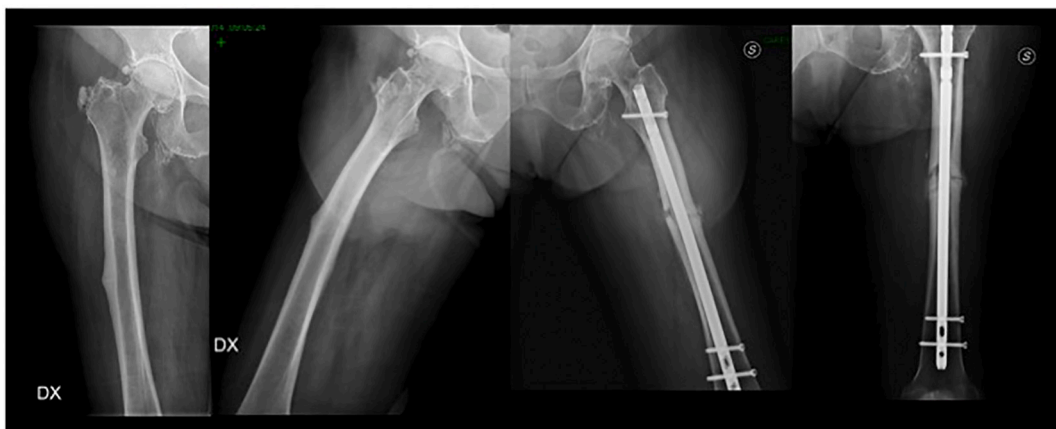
2-months follow-up radiographs. Right: right femur cortical beak. Left: dynamized intramedullary nail.
